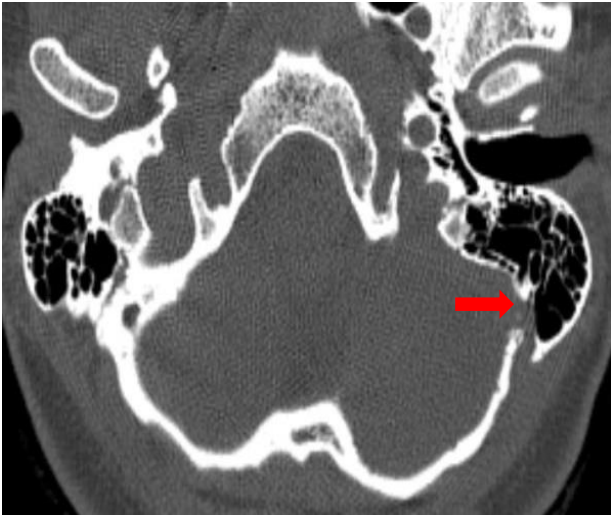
HRCT temporal bone-A prominent emissary vein foramen posterior to the left mastoid sinus.
